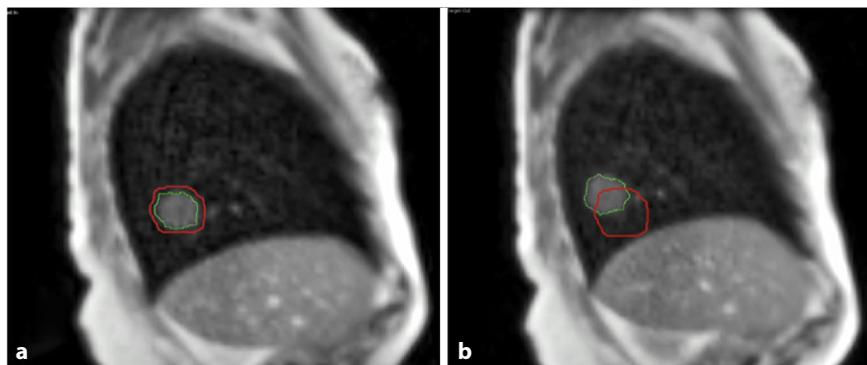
▲ Automated beam gating based on cine-magnetic resonance imaging in a sagittal plane through the tumor. Beam is on while the target (green) is within bounds (red; a) and automatically turned off when the target is outside the defined boundary (b)
